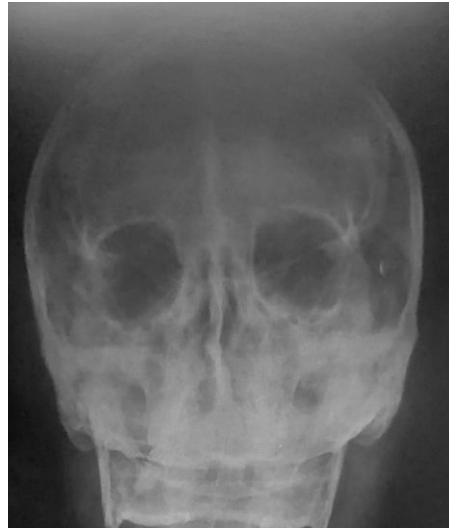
Blondeau's radiograph: absence of pneumatization of the frontal sinus
